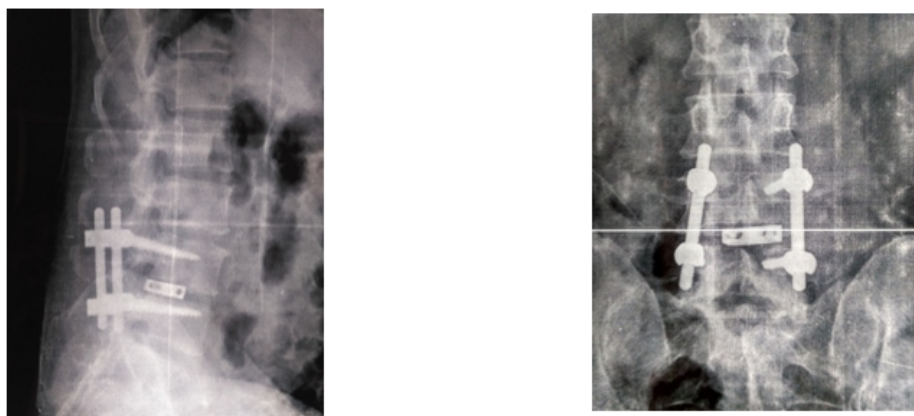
X-ray at 9 months follow up showing possible fusion
